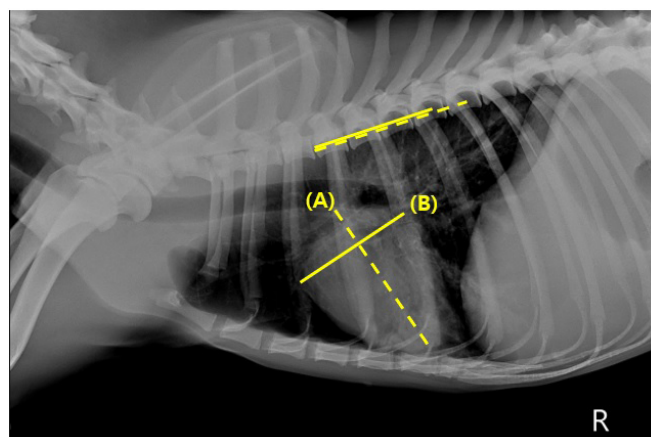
Radiographic measurement of VHS at right lateral thorax. Long axis of the heart (A) connecting ventral border of the left mainstem bronchus and cardiac apex and short axis of the heart (B) at the widest part of cardiac silhouette, perpendicular to the long axis were drawn. Measurements were converted into the length of vertebrae starting from the cranial edge of fourth thoracic vertebrae. Long axis was 3.6 vertebrae long and short axis was 4.6 vertebrae and both lengths were summed for VHS. VHS was calculated to be 8.2 vertebrae.
